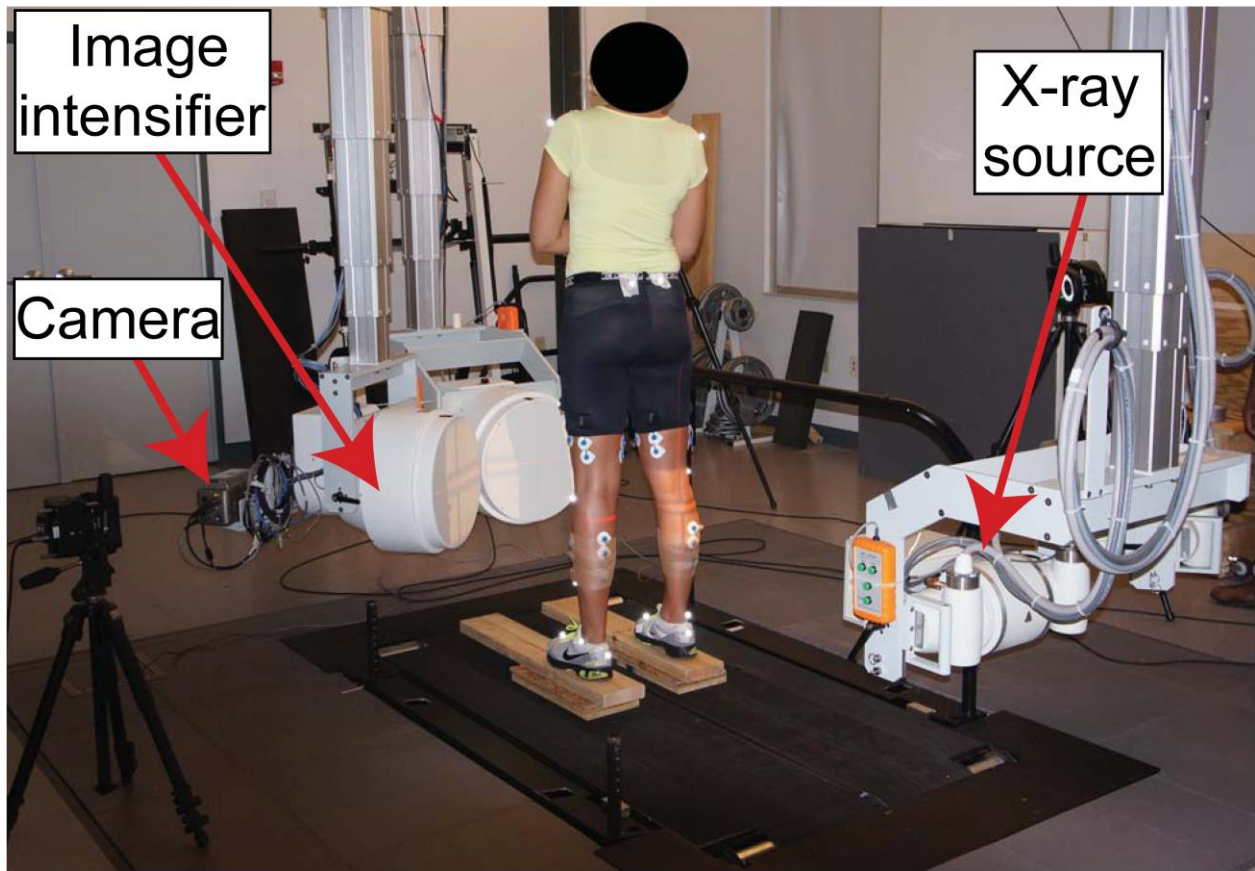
Experimental setup for measuring 3D TF skeletal kinematics during static standing using a dynamic stereo-radiography system.
